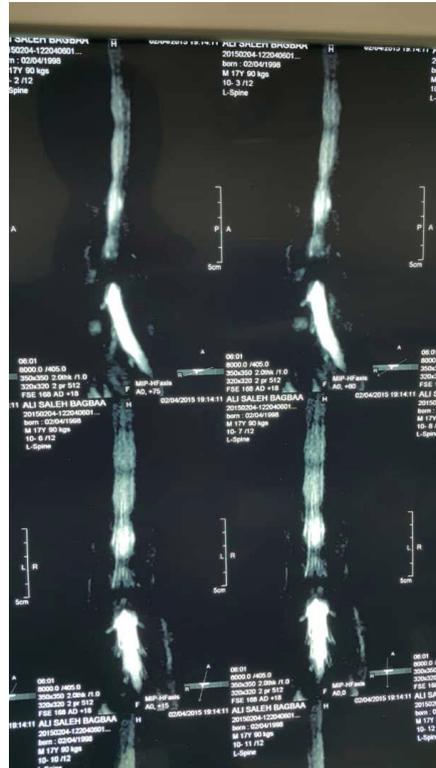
MRI lumbosacral spine myelogram of male patient 18 years old with L4/5 disc herniation.
